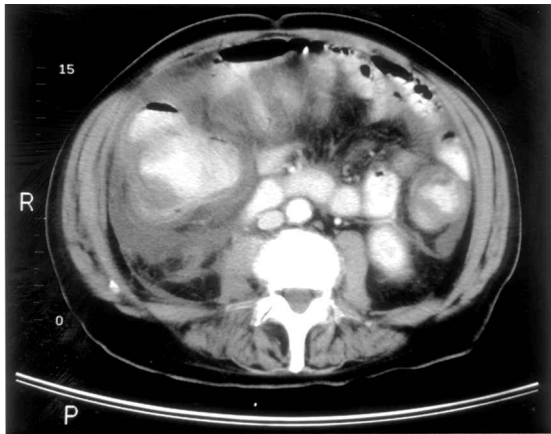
CT scan showing important circumferential parietal thickening of the entire colon consistent with non-specific colitis.
